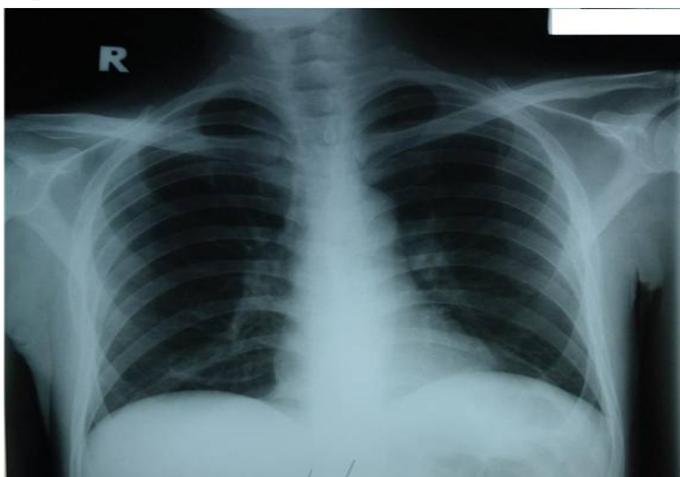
Chest X-ray : Clear lung field, with no focal lesion.
